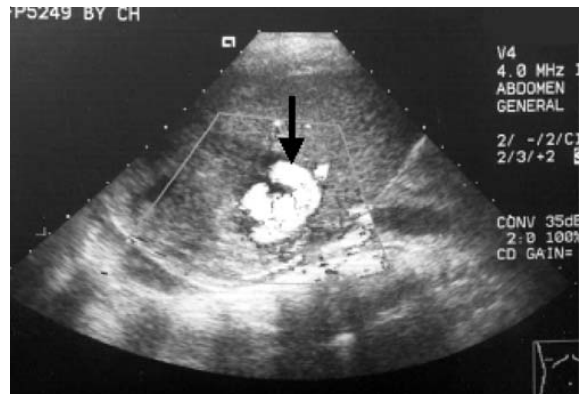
Color Doppler sonogram demonstrates an area in the right lobe, with a turbulent flow (arrow) consistent with a pseudoaneurysm
